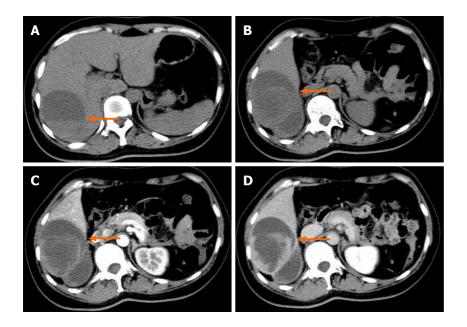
Computed tomography of the upper abdomen before surgery. A mixed low-density lesion (6.5 cm × 9.7 cm × 9.6 cm) can be seen in the right lobe of the liver, within which septations and fluid levels are visible. The enhanced scan showed significant enhancement of the lesion margin and septation (the arrow shows the lesion). A: Plain computed tomography scan; B: Plain computed tomography scan; C: The arterial phase of the enhanced scan; D: Delayed phase.
